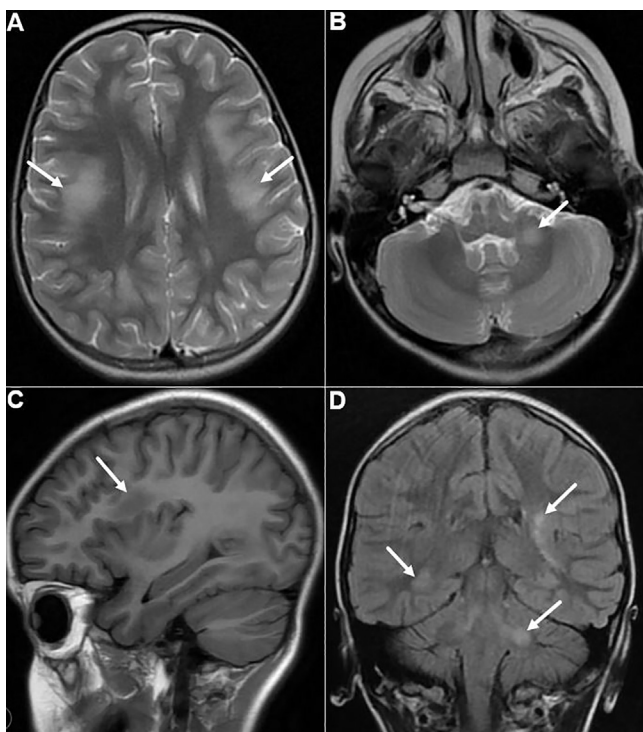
T2 axial (A and B), T1 sagittal (C), and FLAIR coronal MRI images (D) of the brain, showing multifocal bilateral and asymmetrical supra and infra-tentorial WM abnormalities, hypointense on T1 and hyperintense on T2 and T2 FLAIR abnormalities (arrows).
